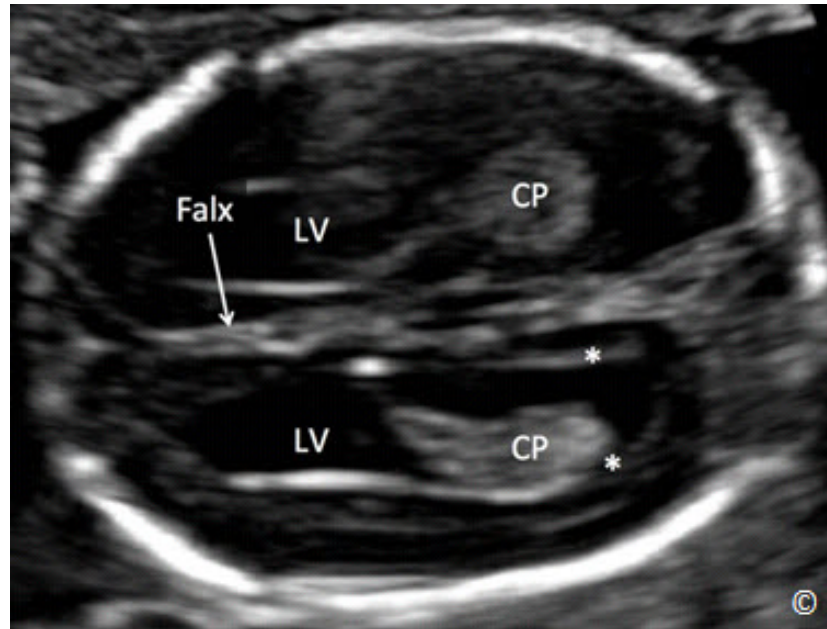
Transverse plane of the fetal head at the level of the lateral ventricles (LV). Sonographic landmarks for LV measurement include the LV, the cavum septae pellucidum and the midline falx (labeled). The LV is measured at the level of the atrium (asterisks). CP = Choroid Plexus.
